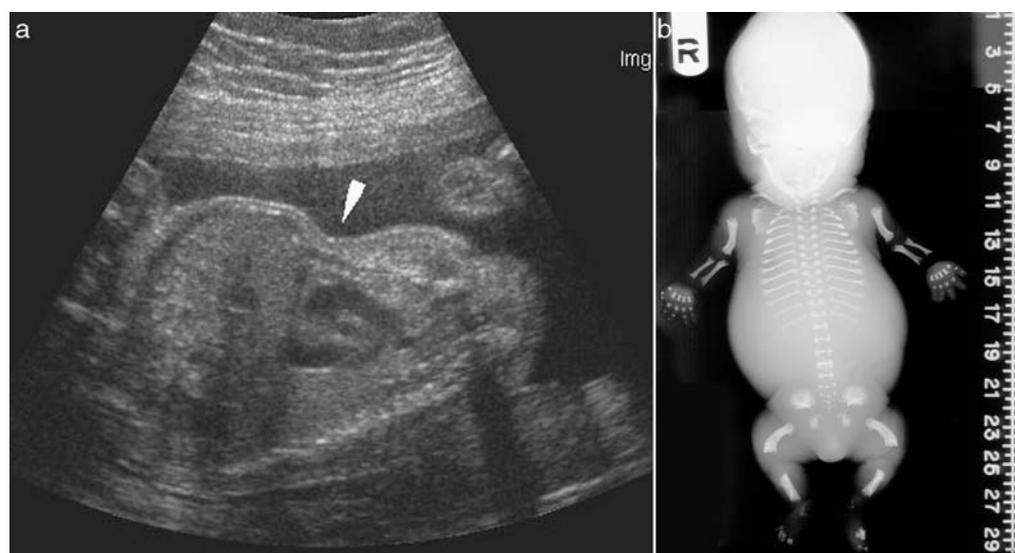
(A) Ultrasound performed at 23.5 weeks due to suspicion of skeletal dysplasia. Mildly shortened femurs were noted at 12 weeks and repeat ultrasound at 19 weeks showed micromelia, small thorax, and marked midface hypoplasia. Based on the findings, the parents were counseled that the fetus had a lethal condition and that thanatophoric dysplasia (TD) was the likely diagnosis. This view of the fetus shows the narrow chest diameter compared to the abdomen. After termination of pregnancy, the diagnosis of type 1 was confirmed by radiographs and molecular analysis. (B) Radiograph of the fetus with TDI. This diagnosis was subsequently confirmed by molecular analysis, which showed the C742T mutation in the FGF-R3 gene (typical of TDI). The radiographic findings are severely shortened limbs with trident positioning of the fingers and bowed femurs. In the thorax, there are H-shaped platyspondyly and short ribs. TD is broadly classified into two types. TD1 causes bent/angulated femurs. TD2 is associated with cloverleaf skull caused by multiple craniosynostoses and relatively straight femurs.
